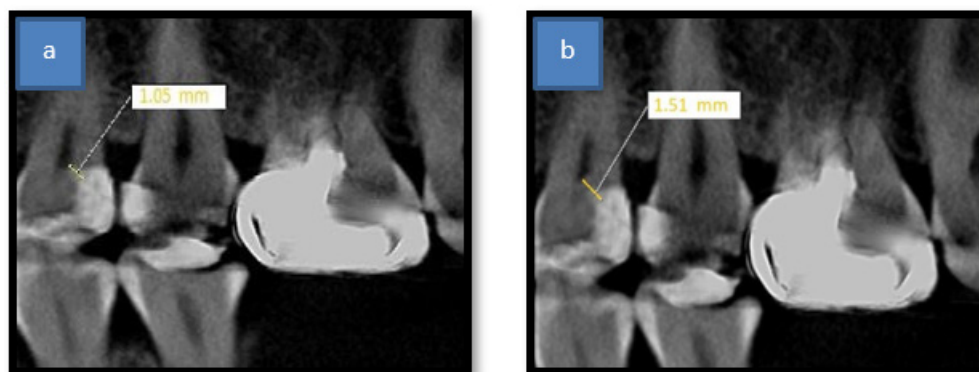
a) CBCT measurement of immediate post-operative remaining dentin thickness, b) CBCT measurement of Six months post-operative remaining dentin thickness
